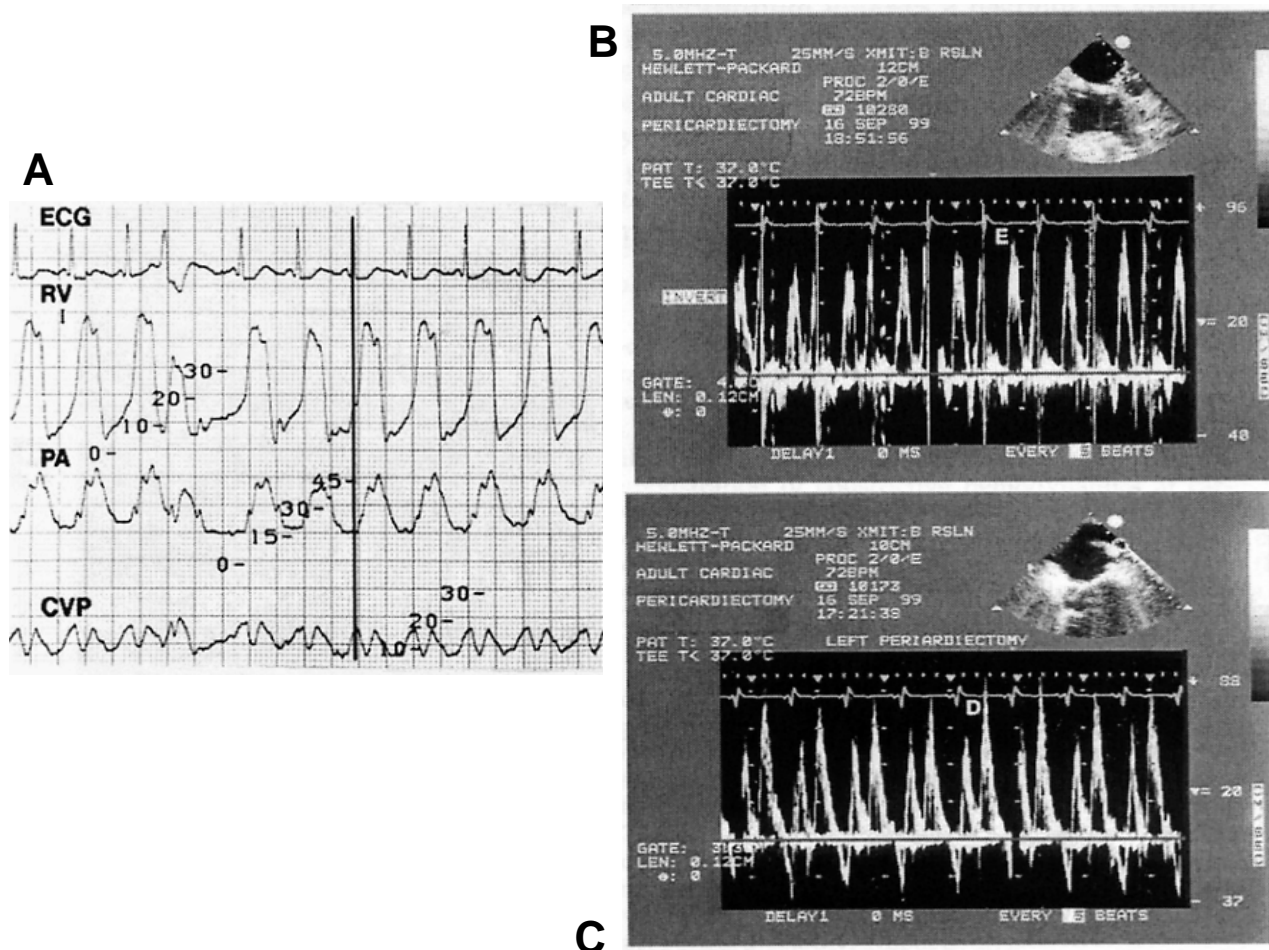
Hemodynamic tracings and Doppler echocardiography immediately after pericardial stripping. A: The “square root” sign has disappeared after pericardial stripping and the “M” waveform of the CVP is less prominent (compare with figure 2). B (trans-mitral flow velocities) and C (pulmonary venous velocities) reveal decreased respiratory variation after pericardial stripping (compare with figures 3 and 4, respectively). Abbreviations as in previous figures. (Adapted with permission from Ref. 8)
